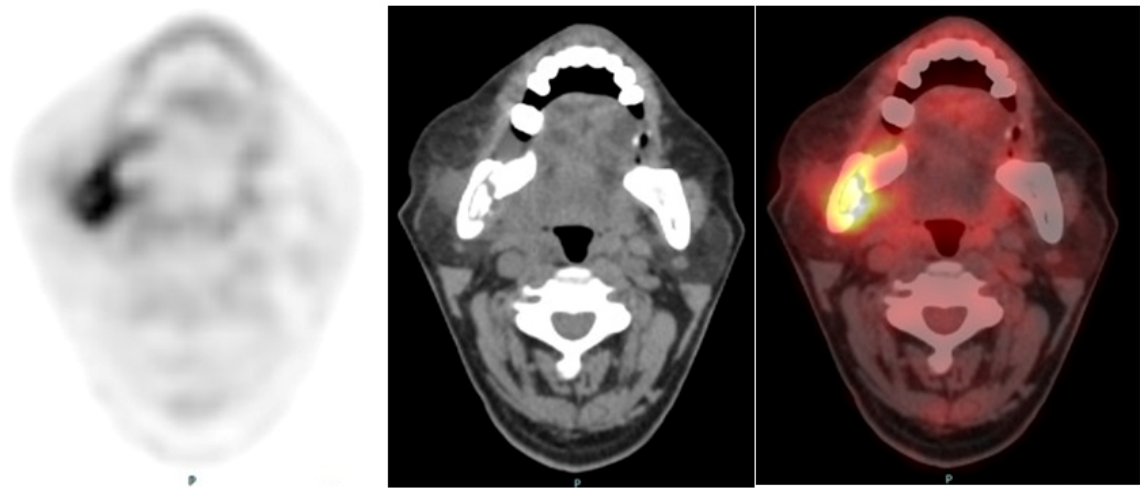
Medication-related osteonecrosis of the jaw (MRONJ) stage 2 in right side of mandible in 63-year-old man who had previously received chemotherapy and denosumab injection for lung cancer for nodular, bony, and hepatic metastases. a) ^{18}F -FDG PET, b) CT, and c) fused-PET/CT images showing osteolytic change and bone sequestrum with significant ^{18}F -FDG uptake on right side of mandible. Calculated quantitative SUVmax, SUVpeak, SUVmean, MLV, and TLG values were 7.73, 6.52, 4.58, 35.90 (cm^3), and 164.44, respectively.
